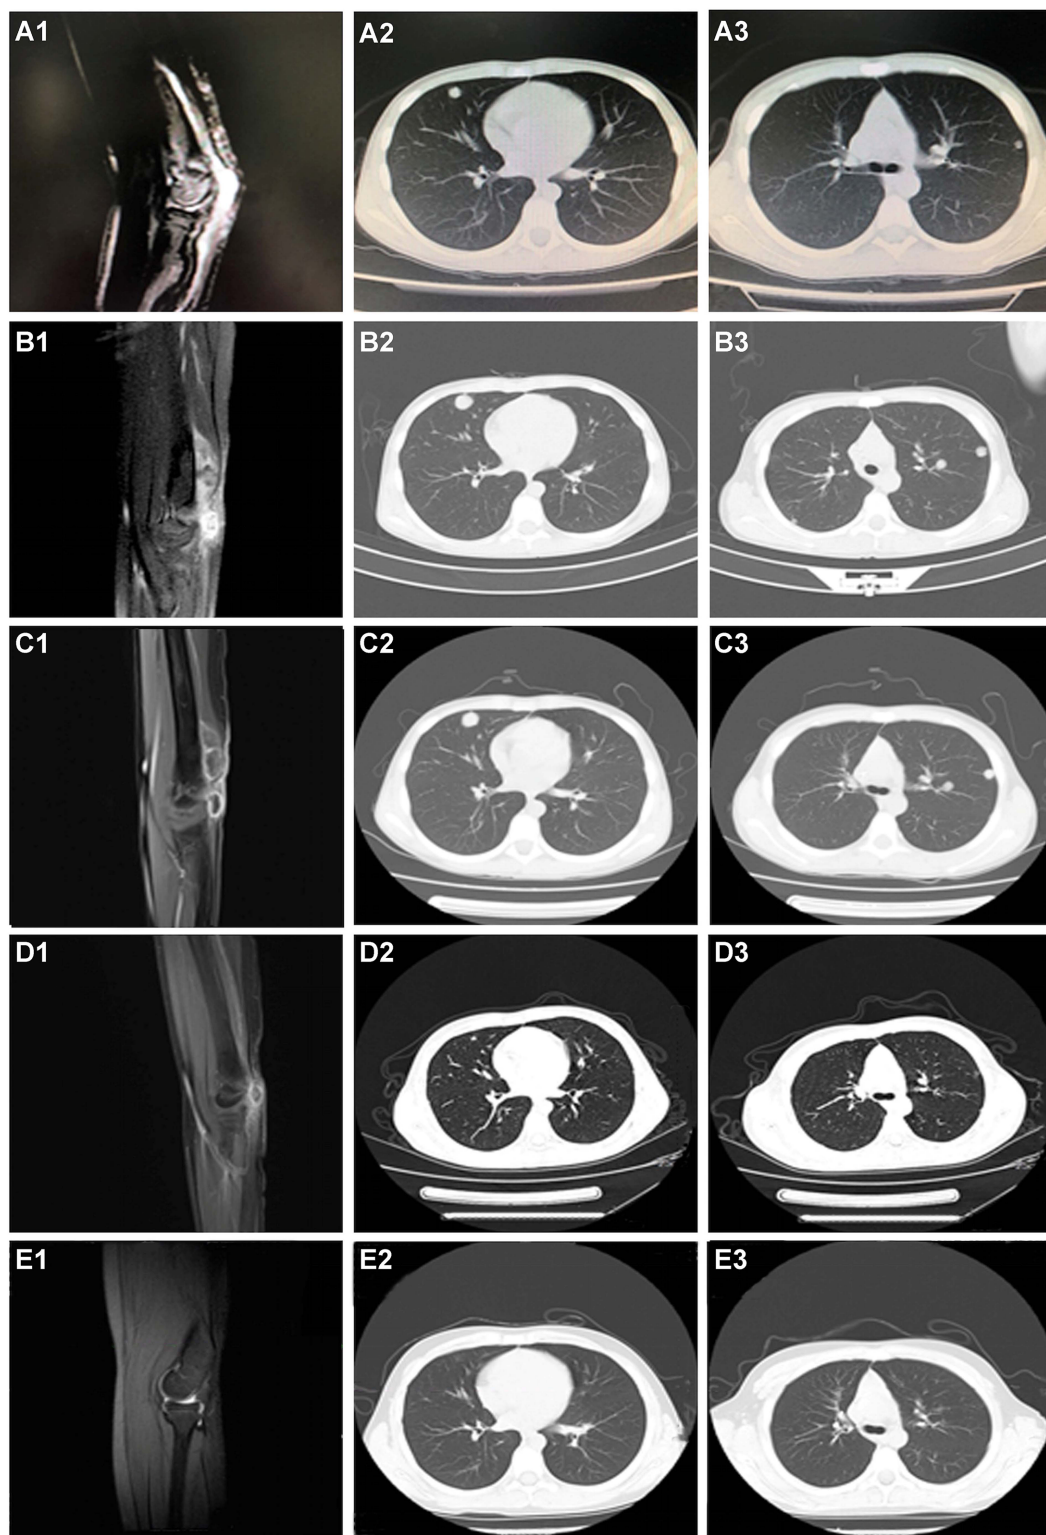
CT scanning during the whole treatment. (A1–A3) Before any systemic treatment. (B1–B3) After one cycle of chemotherapy and endostar. (C1–C3) After 1 month of pazopanib. (D1–D3) After four cycles of nivolumab. (E1–E3) The last followed up scanning. The first column was the limb viewport; the middle and last column was the lung viewport.
